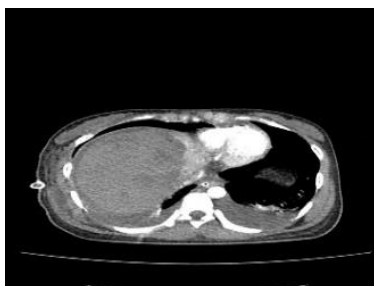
Post angioembolization CT scan showed stable liver injury without evidence of contrast extravasation
